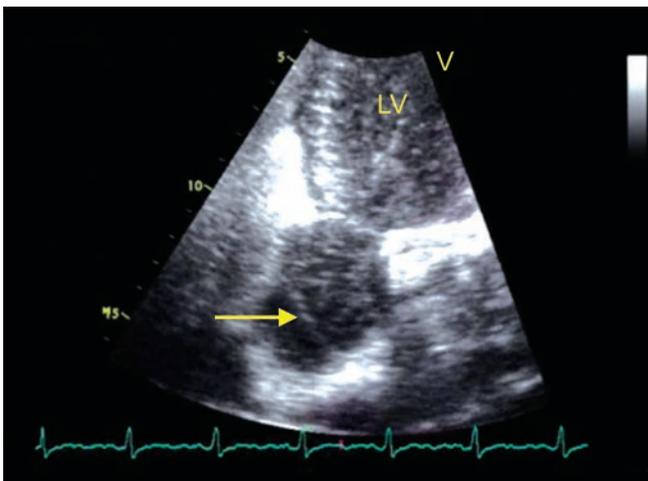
Transthoracic Echocardiography modified apical view, showing left ventricle (LV) and dilated aortic root with a possible intimal flap (arrow).
